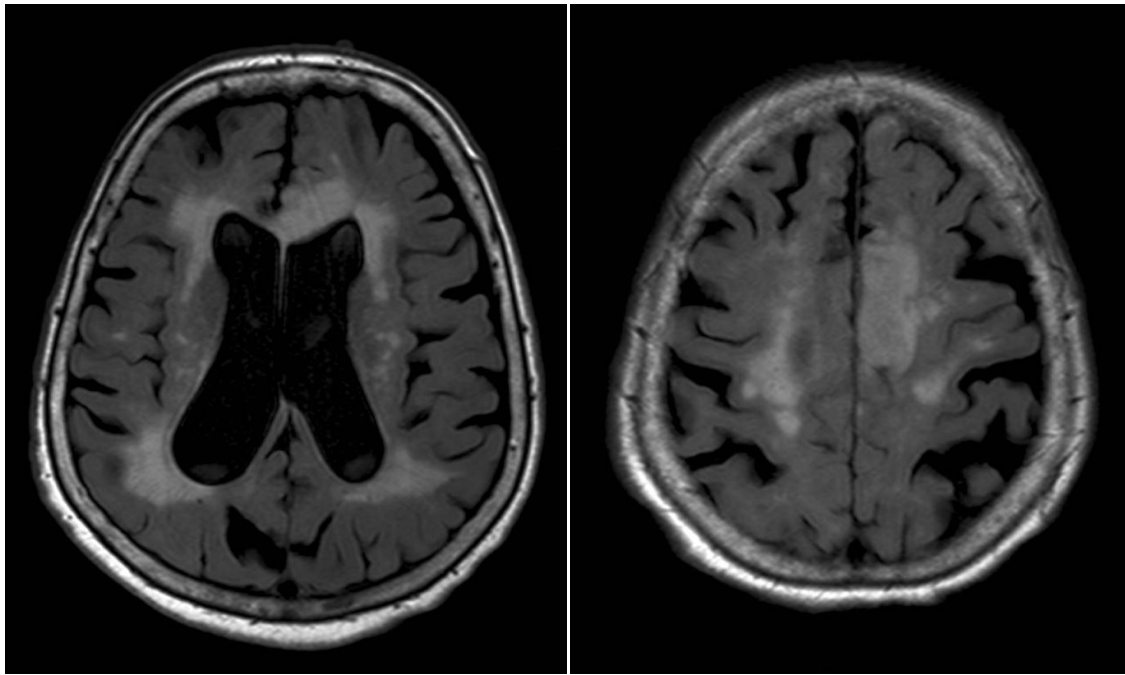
Widespread WMH and diffuse brain atrophy in a 89 year-old hypertensive patient on axial FLAIR images.*
